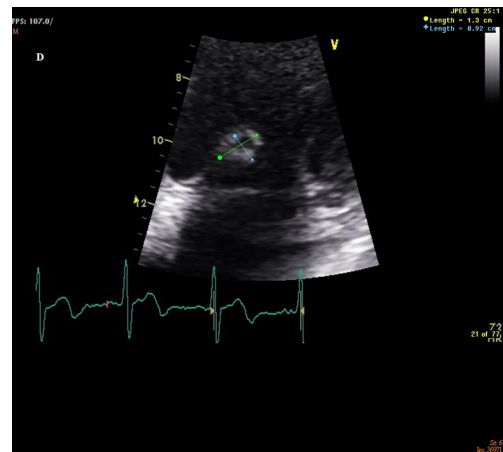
Transthoracic echocardiography showed a vegetation (1.3 cm × 0.9 cm) at anteromedial leaflet of mitral valve.
